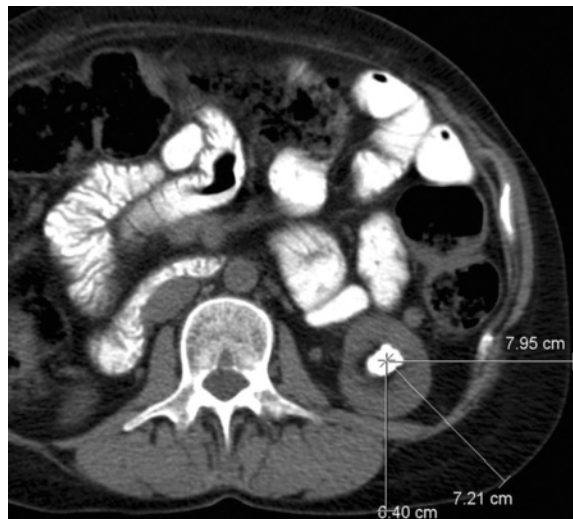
Measurement of SSD in a 65-year-old man with a left lower pole renal stone. On an axial unenhanced CT scan, the distance from the center of the stone to the surface of the skin at 0°, 45°, and 90° is 6.40, 7.21, and 7.95 cm, respectively. The mean of these three values is used to represent the SSD (7.2 cm in this case).
